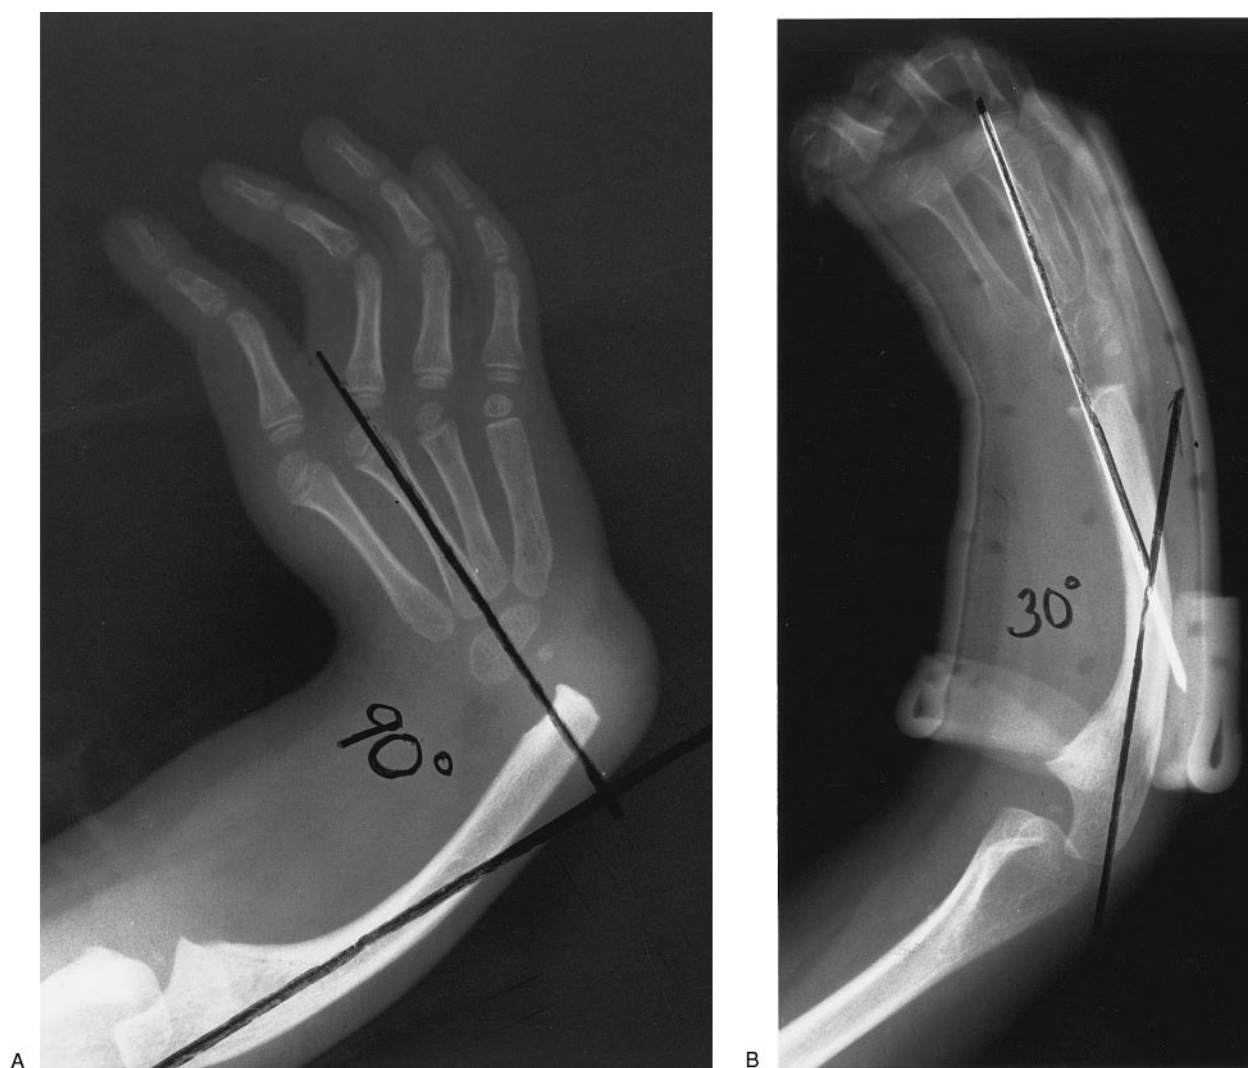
(A) Preoperative x-ray of type IV radial clubhand with 90° of total angulation. (B) Postoperative x-ray obtained after centralization with correction to 30°. (*Figure continues*)
